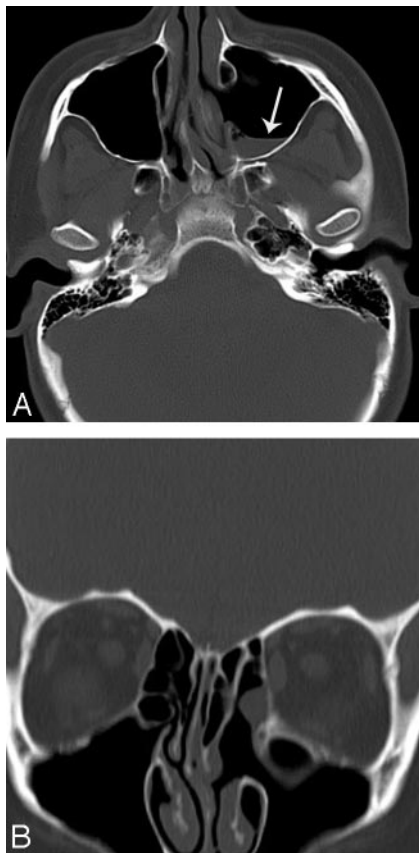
A, Axial CT in an 18-year-old woman performed after head trauma shows a fluid-level (arrow) in the left maxillary sinus. B, Reformatted coronal CT scan shows no evidence of fracture. Changes of previous left functional endoscopic sinus surgery are noted.
